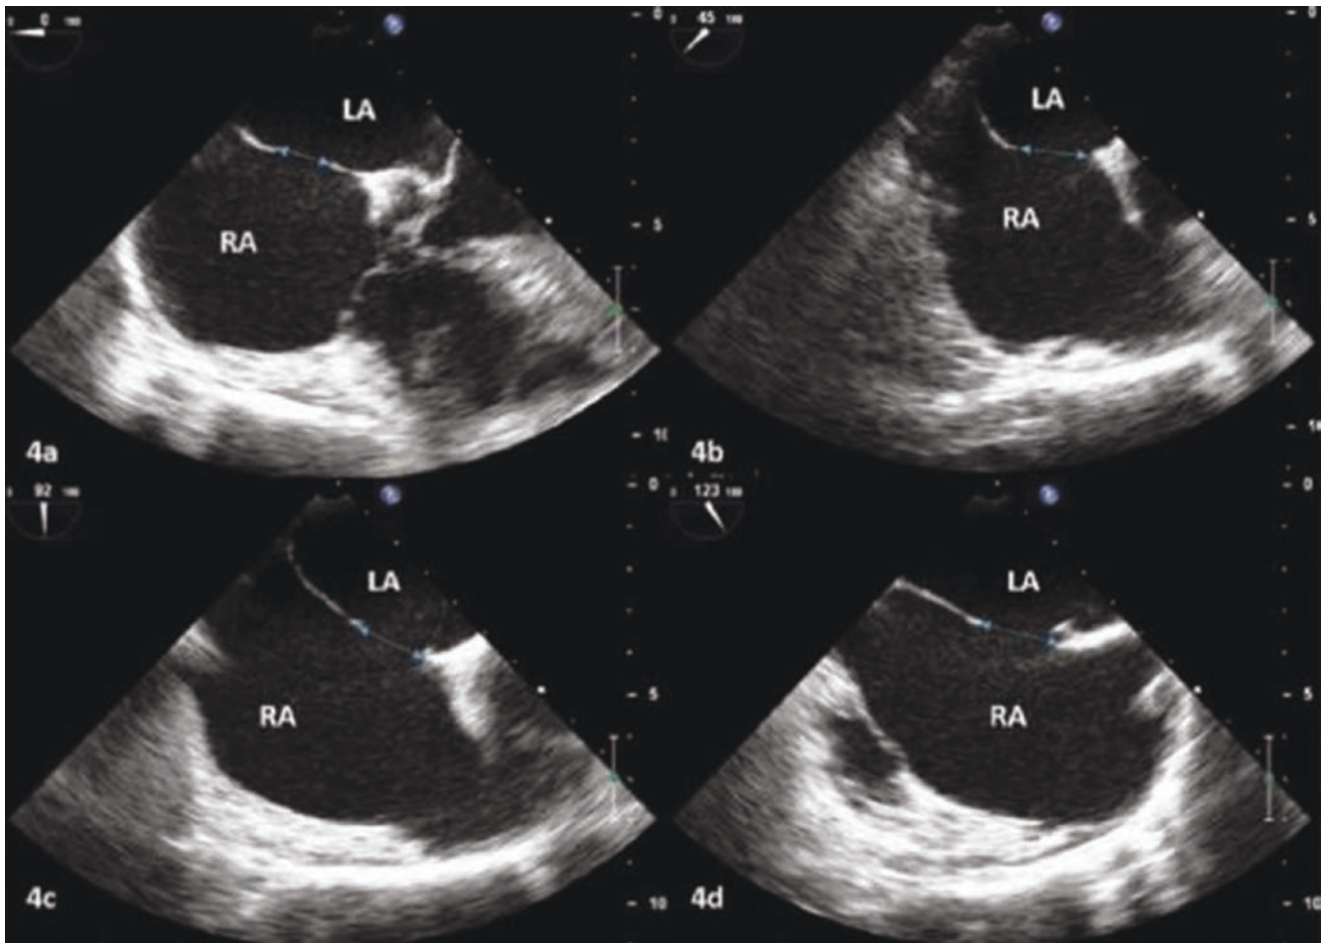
Transesophageal echocardiographic images of ASD (Reprinted with permission from Arun Gopalakrishnan and Kerala Journal of Cardiology [26])
